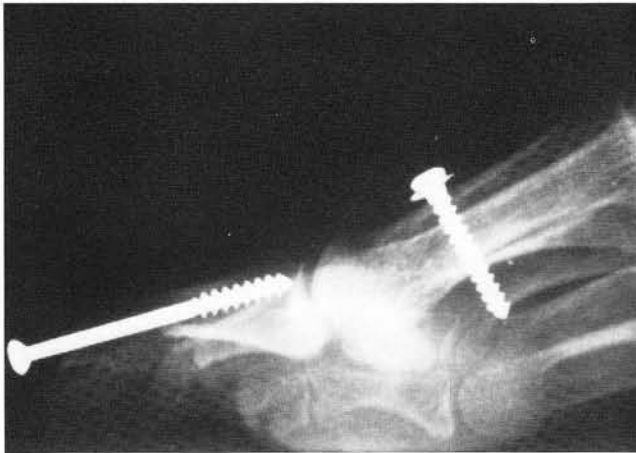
Postoperative x-ray of the author's modifications of the Jones tendon transfer. The tendon was left in place and tenodesed to the metatarsal with internal fixation.
